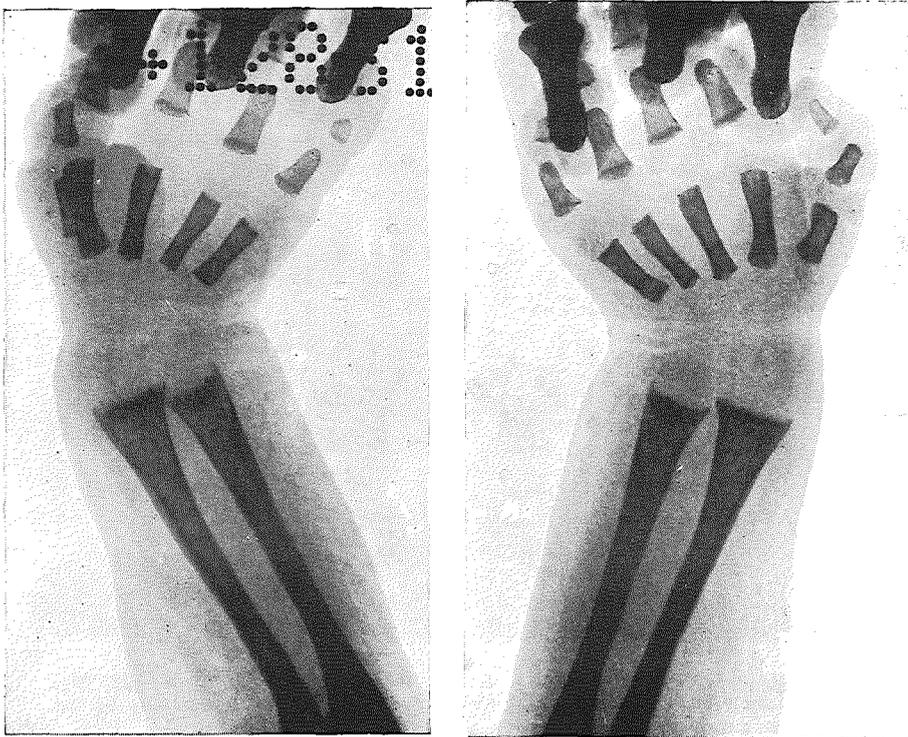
Fœtal rickets in a Chinese baby, X-rayed on the day of birth. Note the uneven frayed diaphyseal ends of the radius and ulna, and the cupping of the latter. (See also Figs. 182 and 186.)
